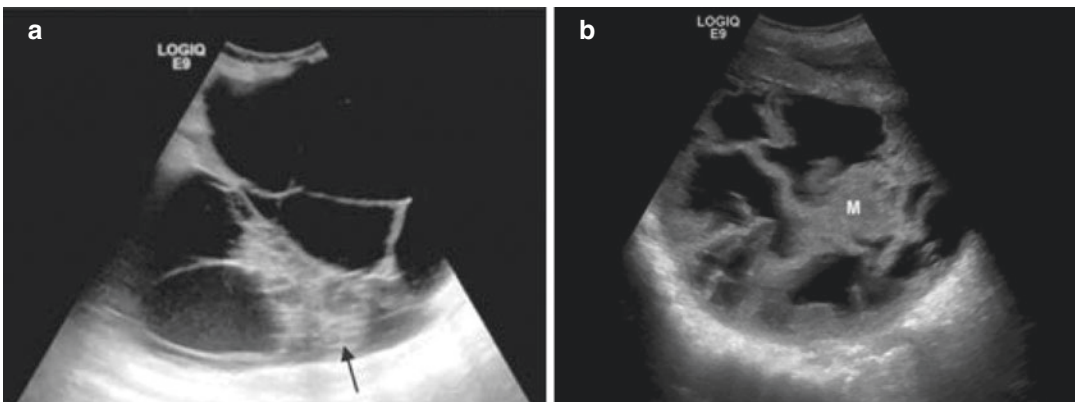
Ovarian cancer. (a, b) Ultrasonography of pelvis showing a complex cystic adnexal mass with thick internal septations and irregular solid components (black arrow)
